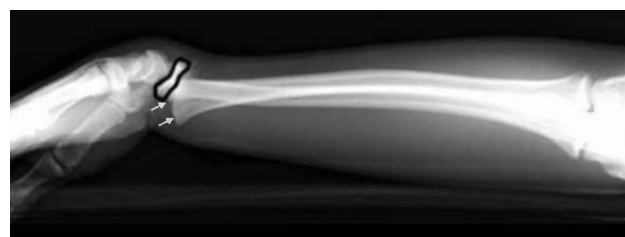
Lateral forearm and wrist with a Salter-Harris type I fracture of the distal radius. Note that the epiphysis (outlined in black) of the distal radius has been displaced into a dorsal position relative to the physis (arrowed) and metaphysis of the bone. The clinician can confuse the epiphysis in this radiograph with a carpal bone, entirely missing the growth plate fracture.
